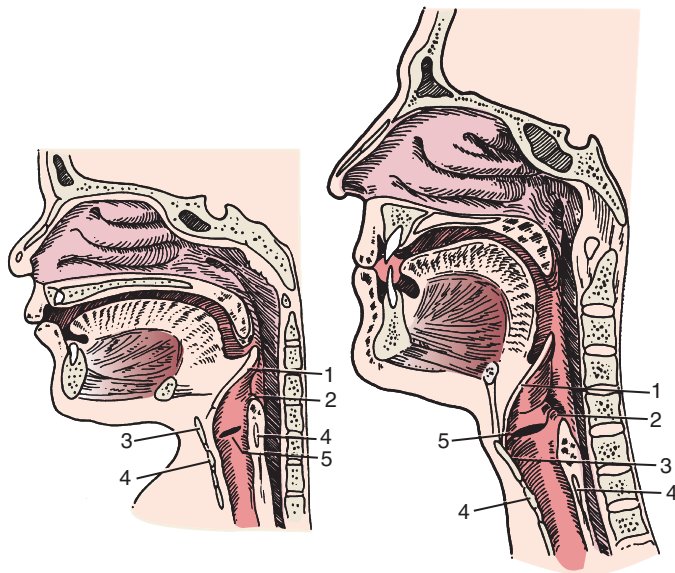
Anatomy of upper airway. Relative comparative anatomy of the larynx in an infant (*left*) and an adult (*right*). Specific landmarks: 1, epiglottis; 2, arytenoid cartilages; 3, thyroid cartilage; 4, cricoid cartilage; 5, laryngeal ventricle, the air space below the false vocal cords and above the true vocal cords. Its radiolucency is an excellent landmark on lateral radiograph. The infant larynx is situated relatively high in the cervical region. In addition, the base of the infant's tongue is close to the larynx, and the epiglottis is located near the palate. These anatomic differences partially explain the predominantly obligate nose breathing of the young infant, as well as the relative ease with which upper airway obstructions develop in infants.
